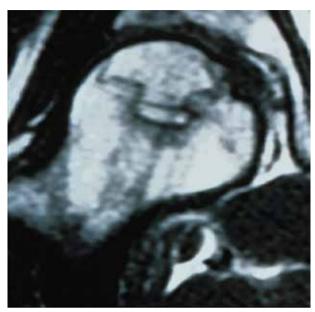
MRI for the diagnosis of FH ON
